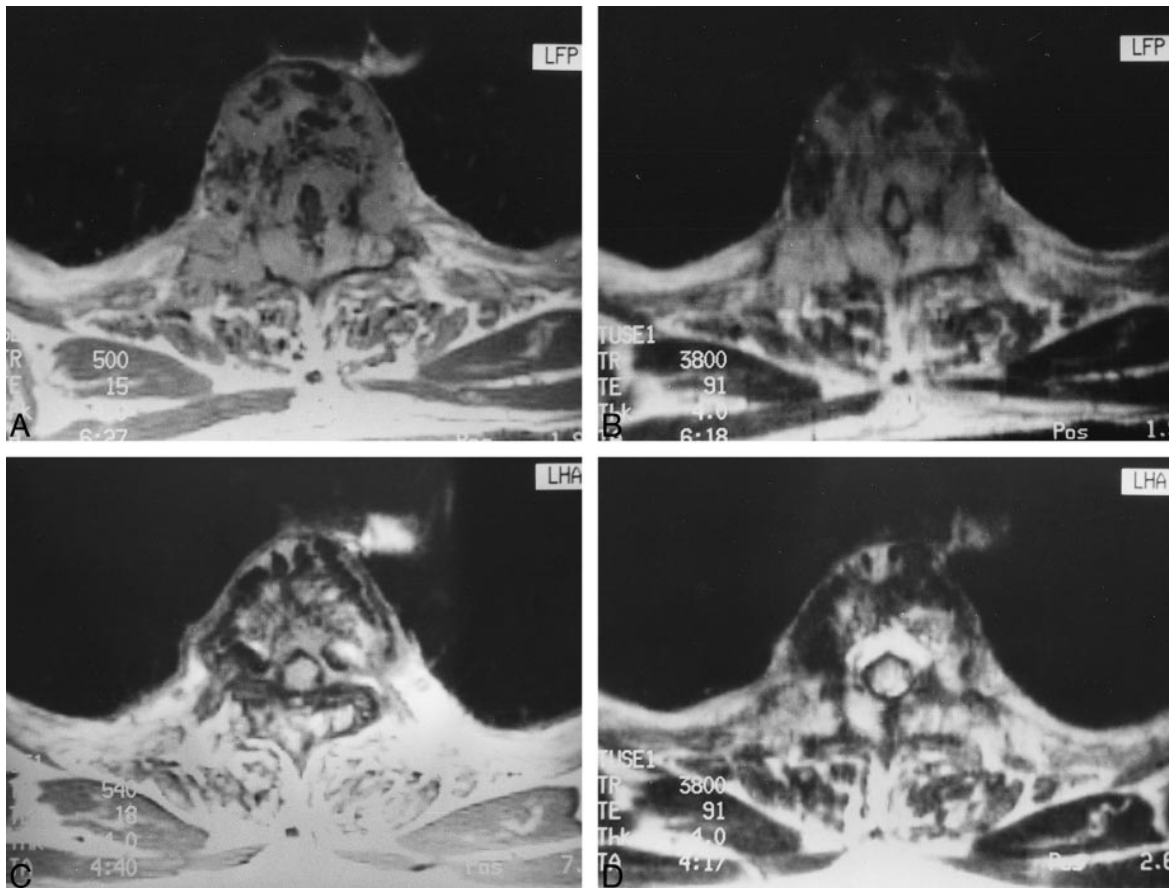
Sequential MR images of a 35-year old woman with SVH who underwent an uneventful alcohol ablation of the lesion. Pre-procedural T1-weighted (A) (500/15/3) and T2-weighted (B) (3800/91/1) axial images at the level of the lesion show the hemangioma with a large epidural soft-tissue component causing compression of the spinal cord. Follow-up T1-weighted (C) (540/18/3) and T2-weighted images (D) (3800/91/1) after an interval of 2 months show a dramatic reduction of soft-tissue hemangiomatous involvement. Note the change in signal in the vertebral-body hemangioma on the follow-up MR images (C and D).
